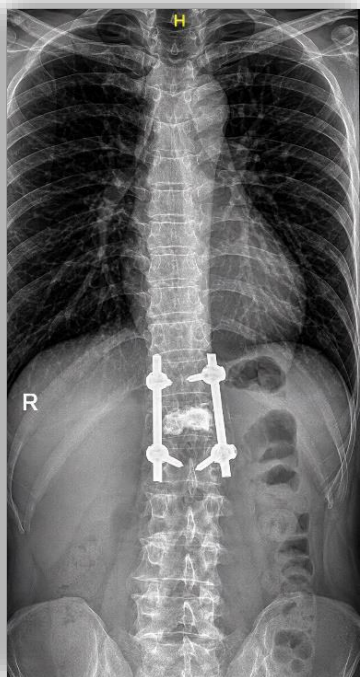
Postoperative thoracolumbar X-ray
